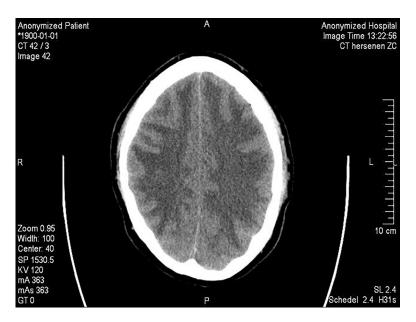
Transversal cerebral CT scan showing extensive vasogenic edema with effacement of ventricles and peripheral sulci and gyri.
